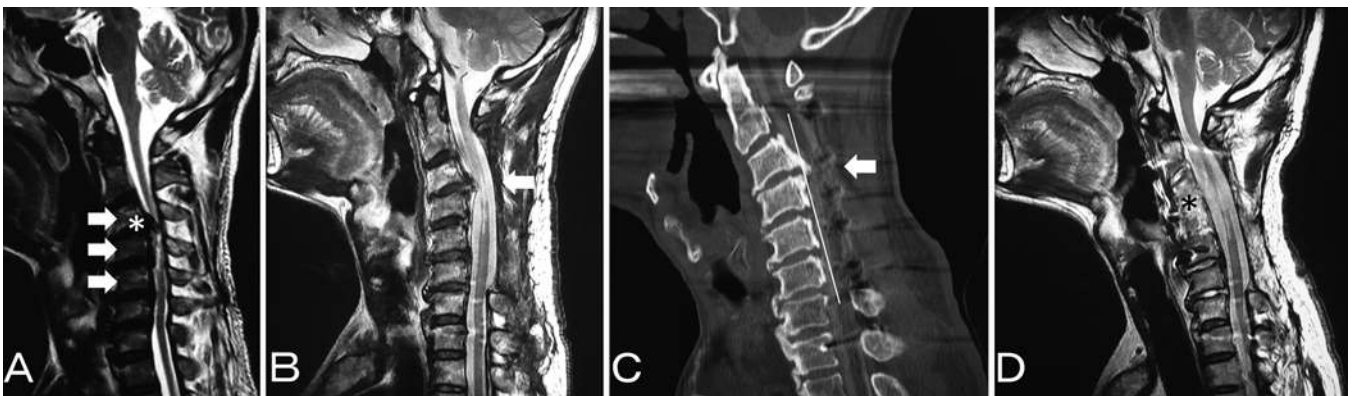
Case 12. A: MR image obtained before initial posterior surgery, showing massive ossification and local kyphosis from C-3 to C-6 (*arrows*). A hill-shaped ossification at C3–4 (*asterisk*) occupies 90% of the spinal canal. B: MR image obtained after posterior surgery, showing insufficient posterior shift of the cord (*arrow*). C: CT myelogram showing persistent anterior impingement of the cord at the C3–4 level (*arrow*). The maximum thickness of the ossified PLL was 10 mm. The K-line (*white line*) was minus. In retrospect, posterior decompression was not suitable for this case. D: MR image obtained after revision ACDF, showing adequate anterior decompression (*asterisk*).
